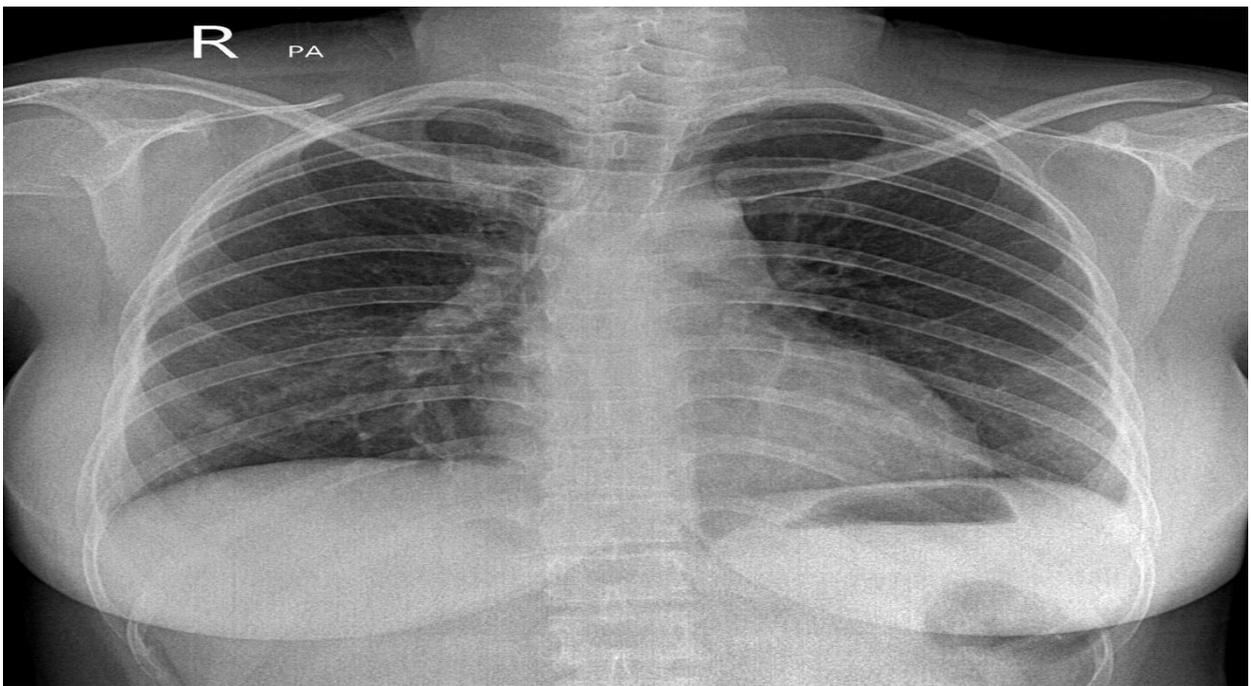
Posteroanterior (PA) chest radiograph at the 9-month follow-up.
